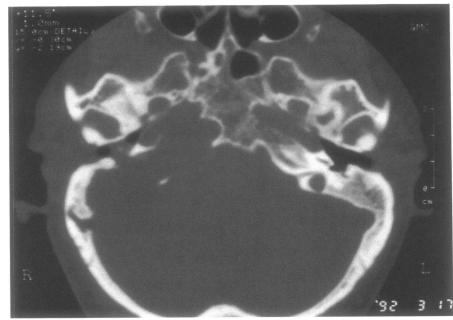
Massive labyrinthine cholesteatoma. Preoperative CT, axial section. All the temporal bone is involved by the disease. The horizontal portion of the carotid artery is surrounded by cholesteatoma, the clivus is eroded and the matrix is adherent to the posterior fossa dura.
